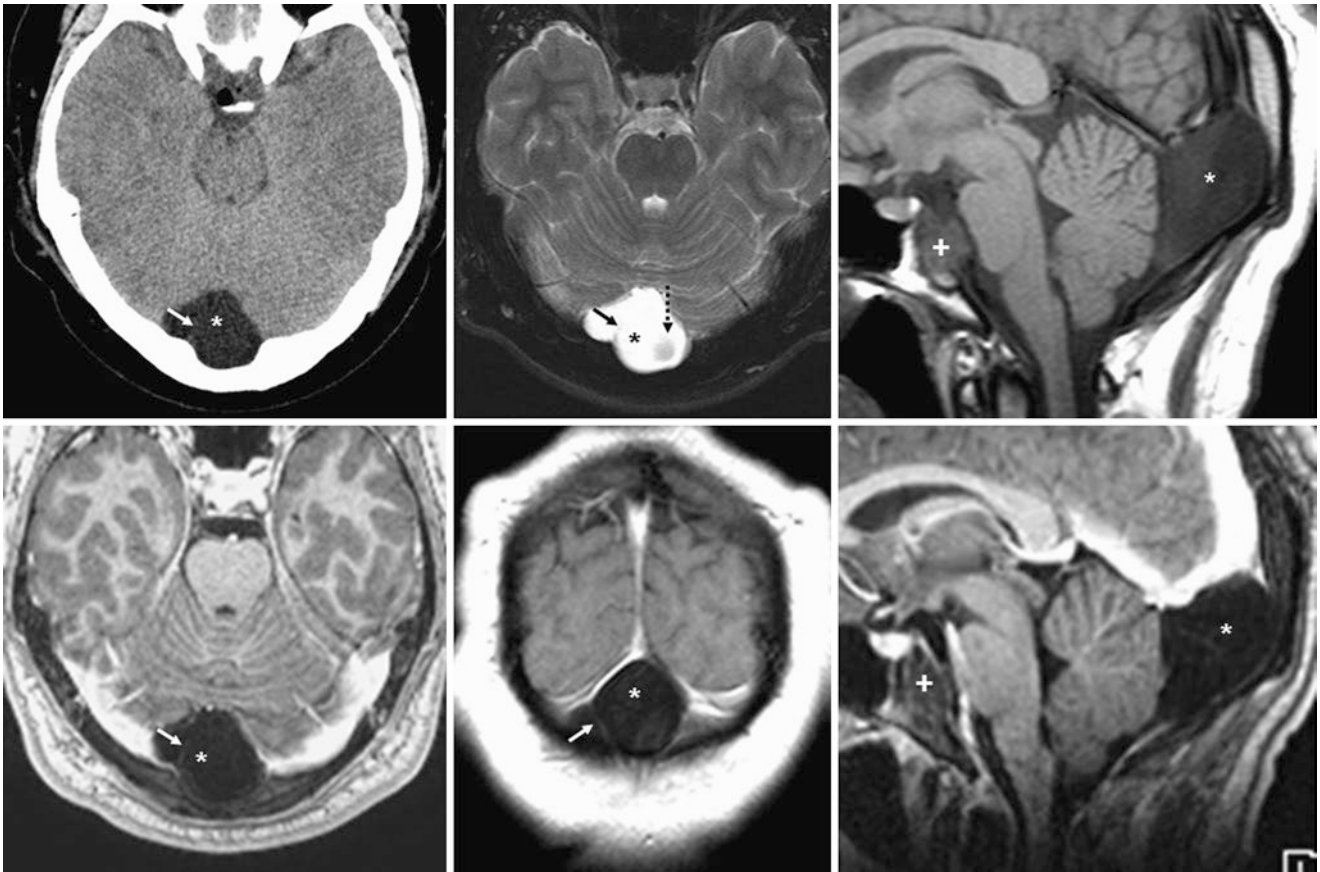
A 21 year old was diagnosed with what was called a retrocerebellar cyst (*), with a prominent posterior fossa and scalloping of the occipital bone on axial NECT (*top left*), MRI T2WI (*top middle*), and sagittal T1WI (*top right*), lacking contrast enhancement on axial (*bottom left*), coronal (*bottom middle*), and sagittal (*bottom right*)
